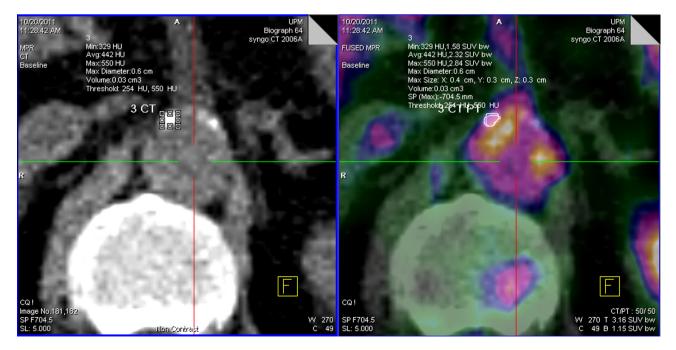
A foci of calcification within vascular wall with CT value of 550 HU (hard plaque) at 10 o'clock position.
